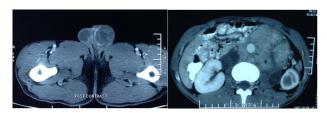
CT KUB: left testicular heterogenous mass & left side retroperitoneal lymphadenopathy.
